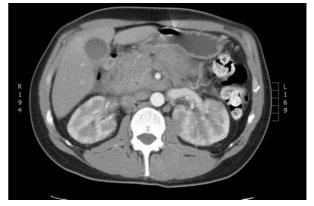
CT scan of the pancreatic mass at presentation.
